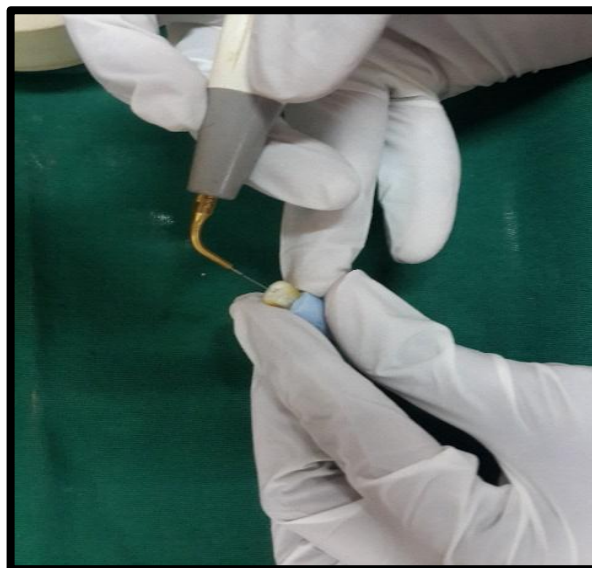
Side vented needle, Irrisafe ultrasonic tips, RFT 2 laser activation tip
